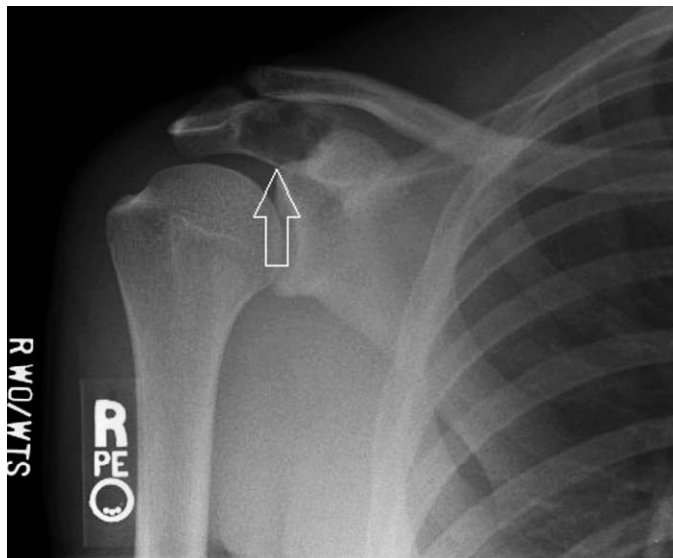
Radiograph of bone lesion in acromial complex.
